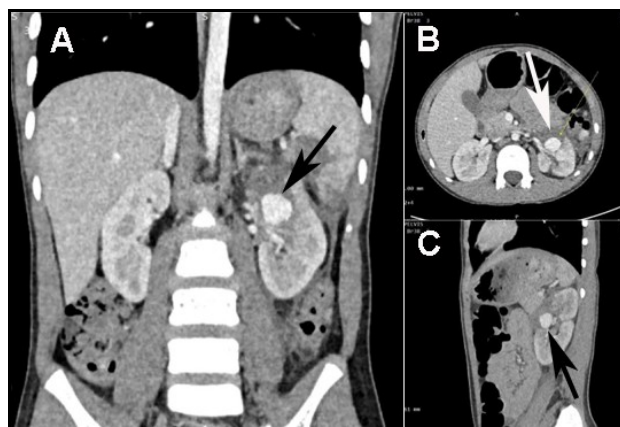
Arterial phase contrast enhanced computed tomography demonstrating the contrast enhancing lobulated lesion in the upper pole of the lacerated left kidney suggestive of a bleeding pseudo-aneurysm (arrows). (A) Coronal view; (B) Axial view; (C) Sagittal view.
